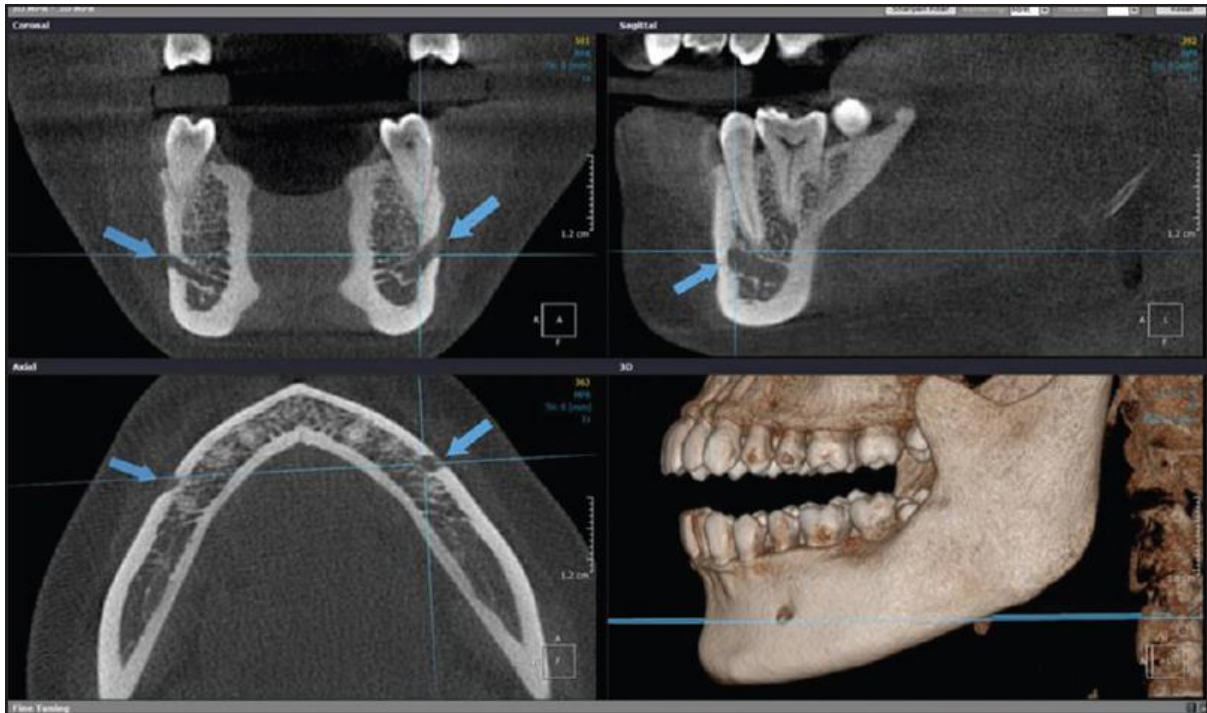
4: CBCT view of MF. Internet accessed, 15 August 2020.
